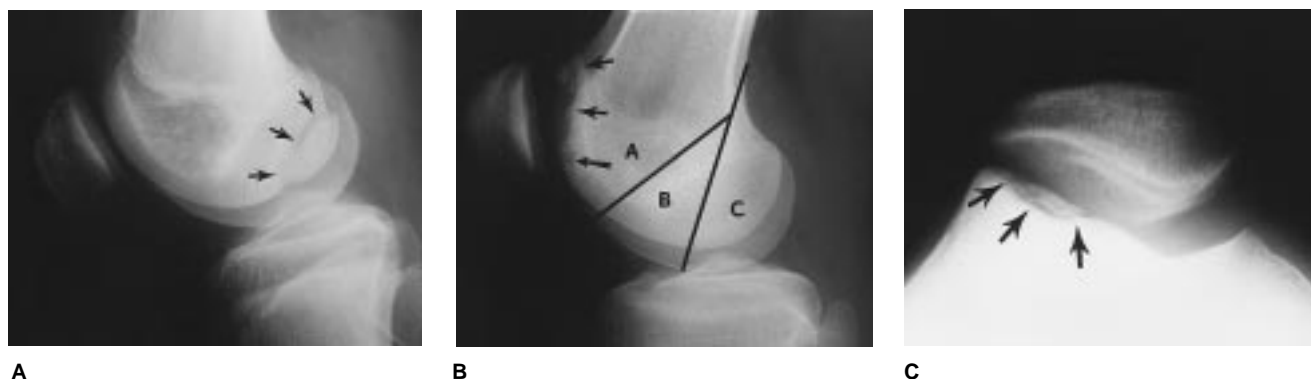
Potentially inaccessible arthroscopic areas (arrows). A, Lateral radiograph of the knee of a 16-year-old male athlete who had been symptomatic for 22 months. The JOCD lesion located in area 1-2 C of the medial femoral condyle. A fragment mismatch and displacement can be seen. B and C, Images of the knee of a 15-year-old boy who had been symptomatic for 18 months. Lateral (B) and axial (C) radiographs show an arthroscopically inaccessible lesion in area 4-5 A of the condyle, with fragmentation of the lesion.
